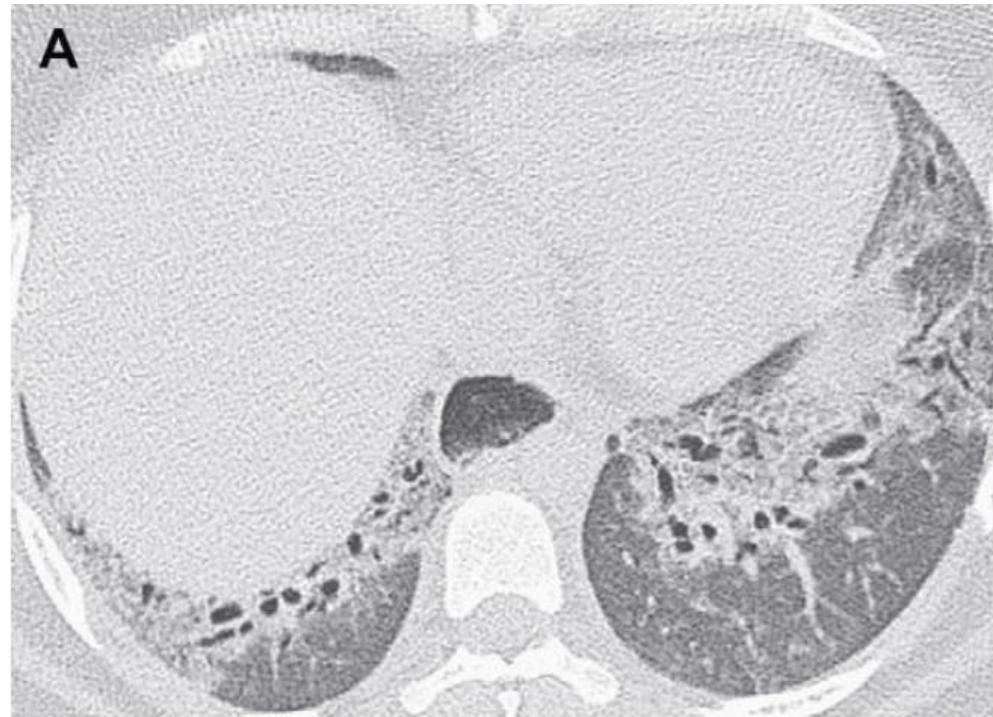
Bronchiectasis out of proportion of surrounding fibrosis. Transaxial CT of the chest of a 34-year-old woman with scleroderma shows a dilated esophagus, basilar pulmonary fibrosis, and significant bronchiectasis without evidence of honeycombing (A). The volume-rendered image demonstrates the extent of the bronchiectasis (A) and the markedly dilated esophagus.
